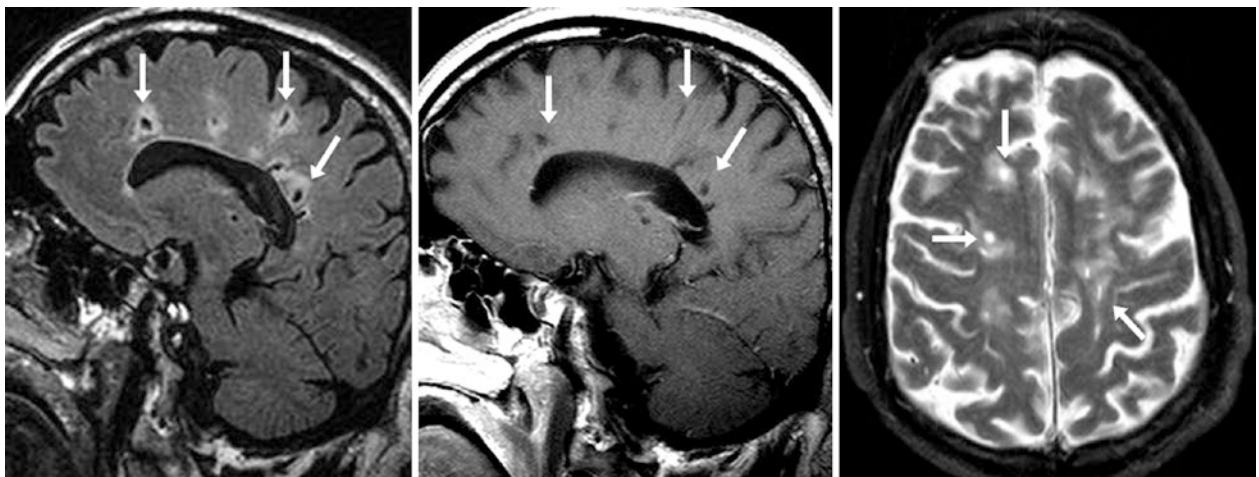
Comparison case of black holes in MS. A 48 year old had multifocal hyperintensities surrounding a black hole (arrows) on sagittal FLAIR MRI (left) that were severely dark on sagittal T1WI (middle)
